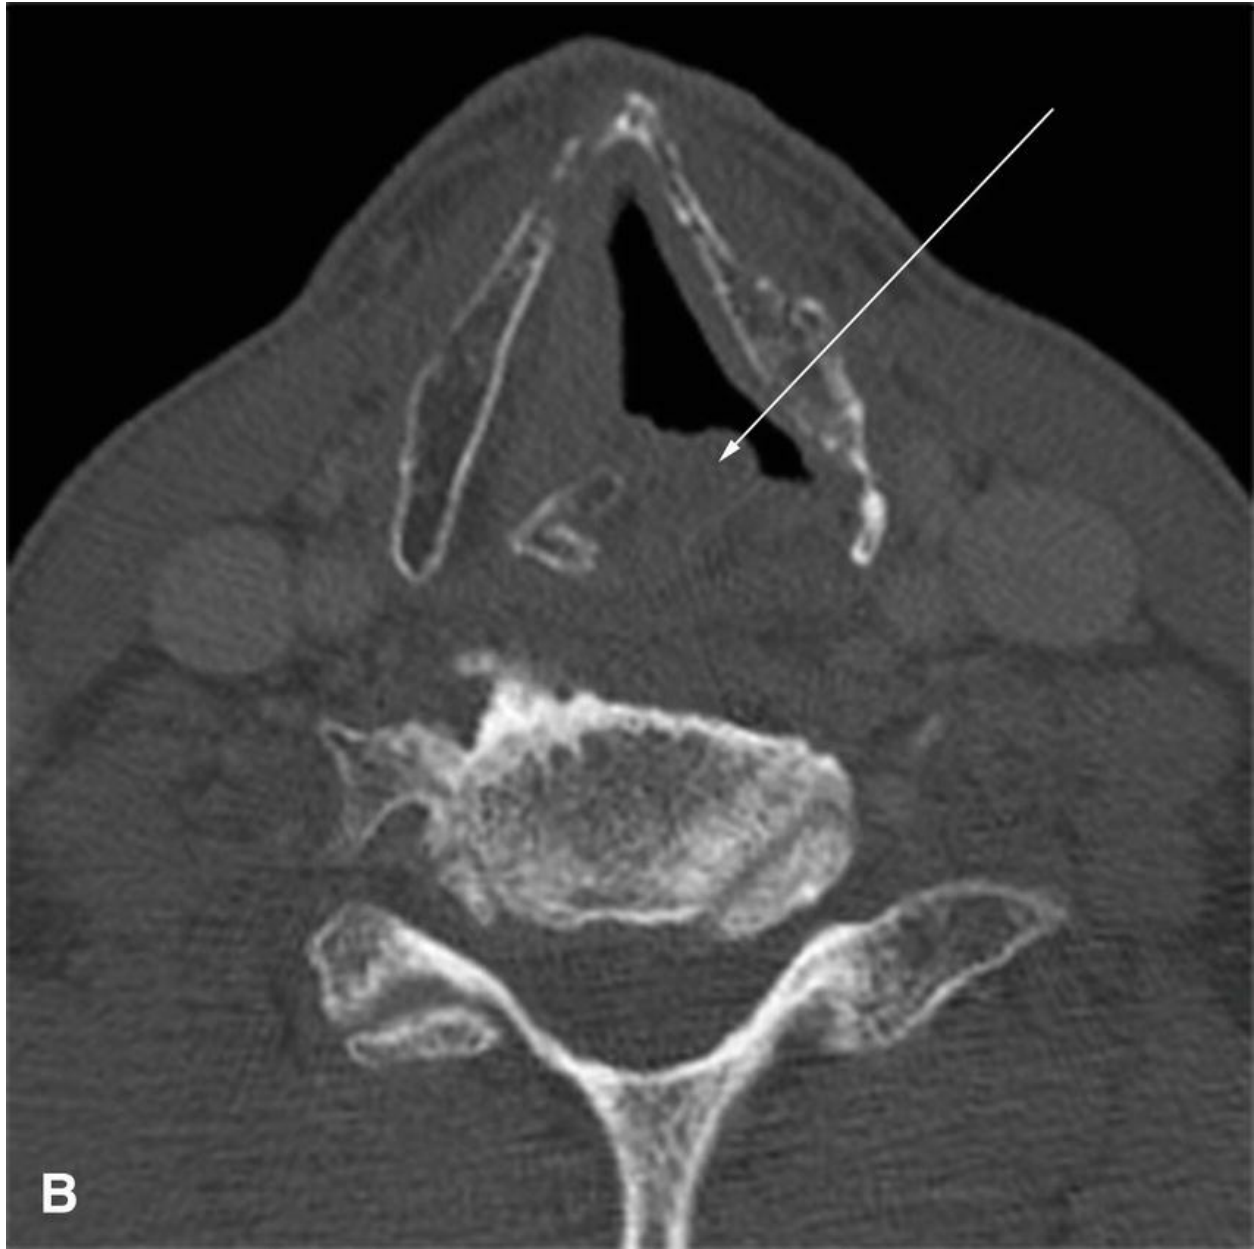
A 58-year-old man with squamous cell carcinoma of the right lateral tongue status post wide local excision, right neck dissection, and radiation therapy. A: A CT of the neck with contrast in soft tissue windows reveals intraosseous air in the mandibular marrow space (*arrow*). B: Bone windows better reveal irregular lytic changes within the mandible, compatible with osteoradionecrosis. The cortical disruption of the pathologic fracture is seen on this image (*arrow*). C: A coronal reconstructed image of the CT of the neck reveals orocutaneous fistula to the submental region (*arrow*).
